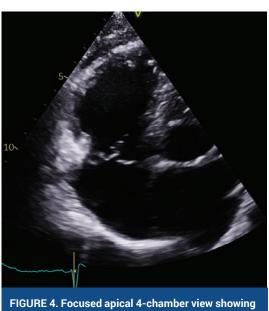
Focused apical 4-chamber view showing the dilated right ventricle and prolapse of the tricuspid valve.
